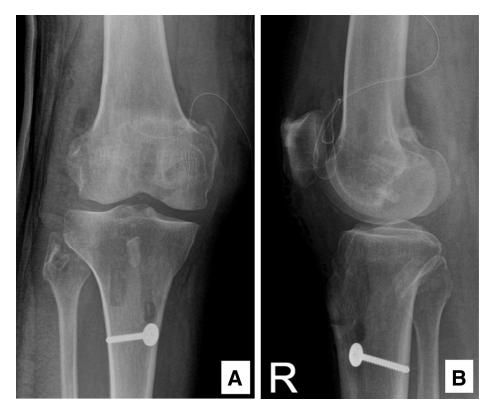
Postoperative radiographs of (A) anteroposterior and (B) lateral views of the right knee following a successful bone—patellar tendon—bone graft.
